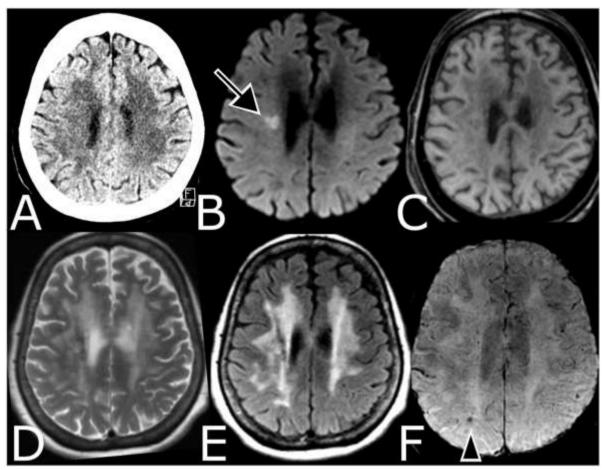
Unenhanced multi-contrast NeuroMix sequence compared to CT in a 67-year-old female with history of prior strokes and worsened left-sided weakness and dysarthria. Graded as unique NeuroMix information regarding acute infarct (arrow) and microhemorrhages (long arrowhead, other sites not shown). A) Axial non-contrast CT head without focal hypoattenuation or CTP deficit (not shown). B) DWI with diffusion restriction in the right corona radiata (arrow). C) Axial reconstruction of NeuroMix sagittal 3D T1 weighted acquisition. D) T2-weighted and E) T2-FLAIR images show confluent subcortical white matter hyperintensity. F) SWI shows a right parietal microhemorrhage (arrowhead).
